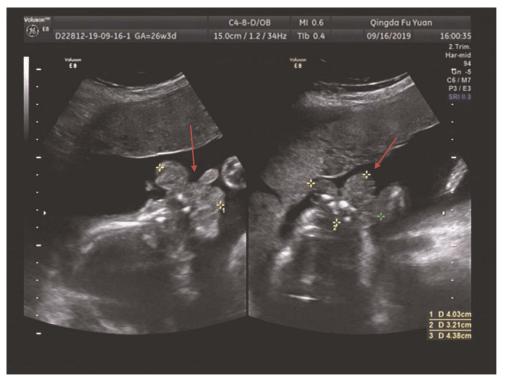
Well-defined mass measuring $4.03 \, \mathrm{cm} \times 3.23 \, \mathrm{cm} \times 4.38 \, \mathrm{cm}$ by ultrasonography and arising from the fetal oral cavity at 24 gestational weeks. The arrows indicate the mass.
